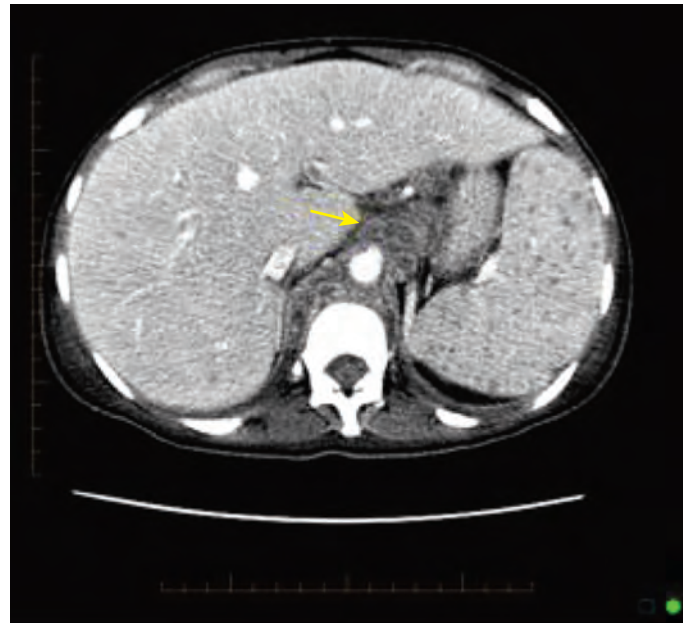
Disseminated miliary tuberculosis. Contrast-enhanced CT demonstrates multiple hypodense nodules. Notice the associated para-aortic and retrocrural hypodense lymphadenopathy (arrow).
